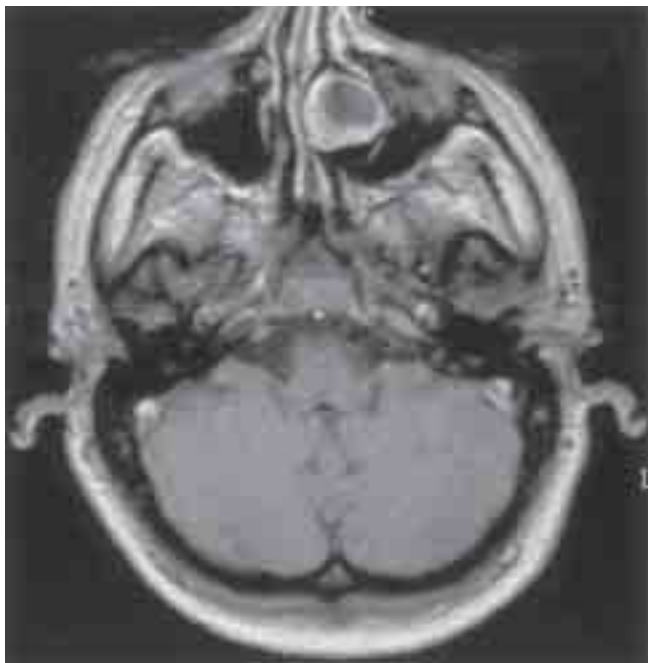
T1-weighted axial MRI of Case 1 showing the unusual feature of peripheral rim enhancement of olfactory neuroblastoma following contrast.
